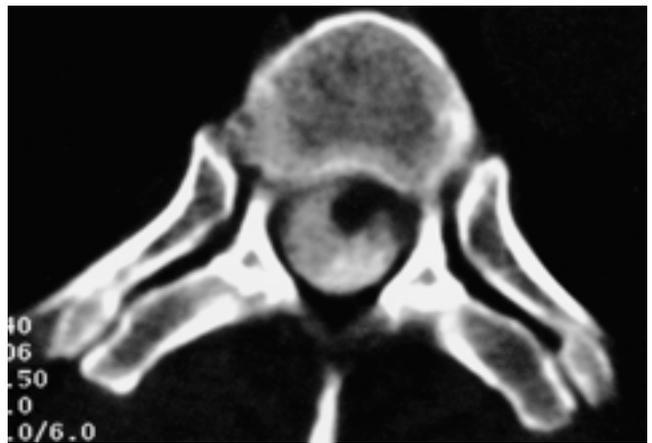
Computed tomographic myelogram shows the anterior displacement of the spinal cord and tongue-like projection of the spinal cord through ventrolateral dural defect.
